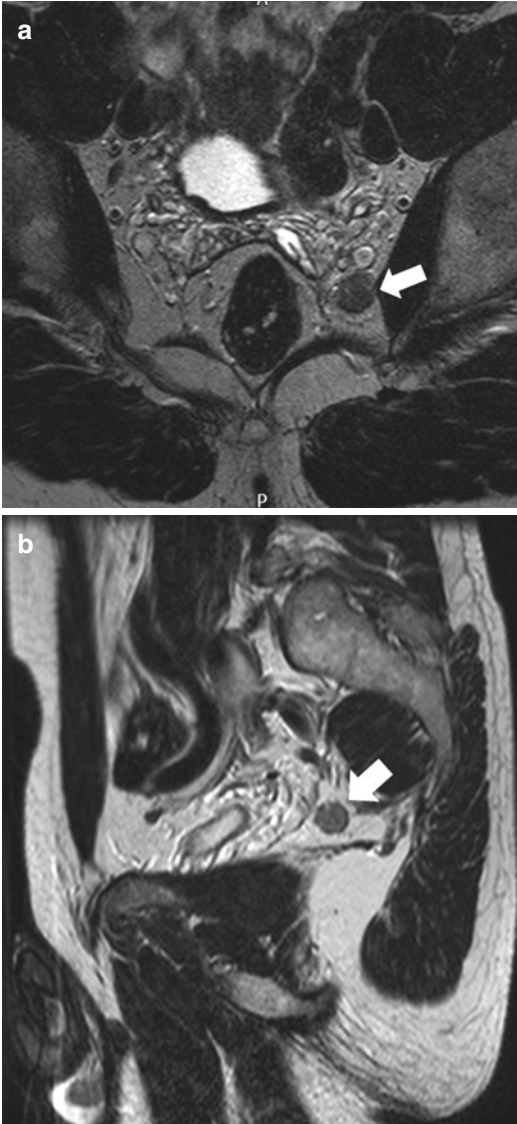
Axial (a) and Sagittal (b) T2-weighted MRI section showing a 14mm metastatic left pelvic side wall lymph node (*white arrow*). Note the heterogeneous signal intensity and irregular border which is suggestive of tumour infiltration. (Images courtesy of Mr. B Moran, Basingstoke and North Hampshire Hospital, U.K.)
